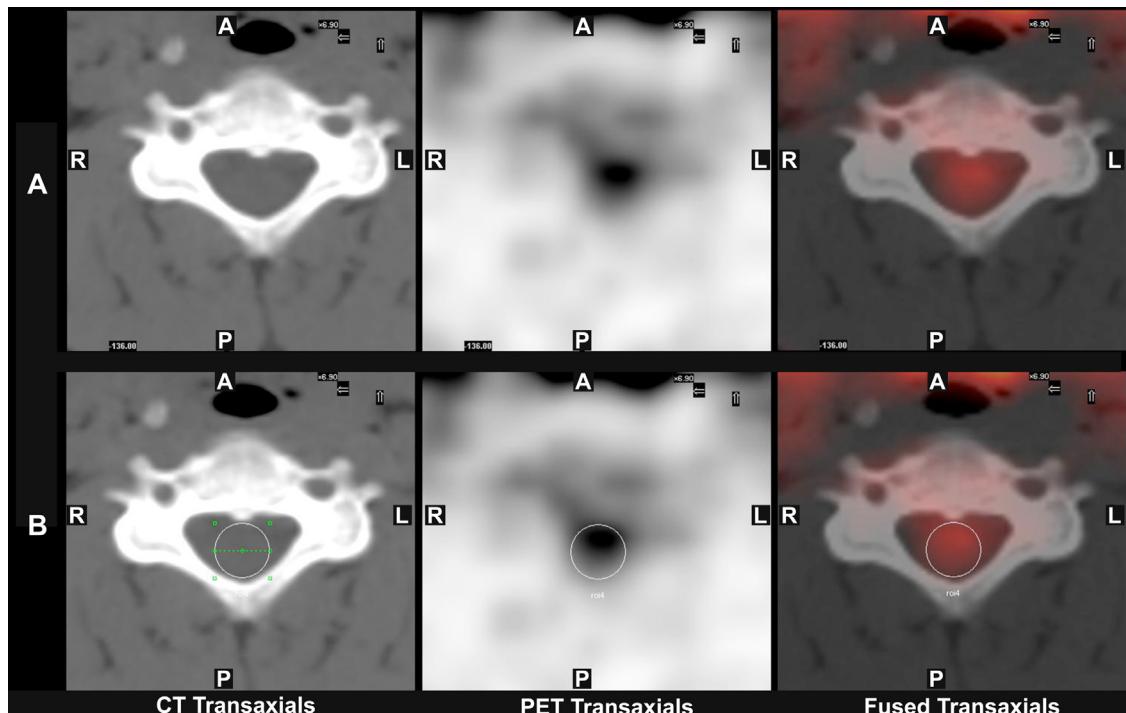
Placement of ROIs. (A) Single transaxial ^{18}F -FDG PET/CT image obtained within the spinal cord. (B) Placement of an ROI (white circle) within the spinal canal on both the non-contrast CT image and attenuation corrected PET image. Data obtained from the ROI include total counts, SUVavg, SUVmax, and area. Designations of 'A', 'P', 'R' and 'L' represent the subject's anterior, posterior, right and left sides, respectively.
